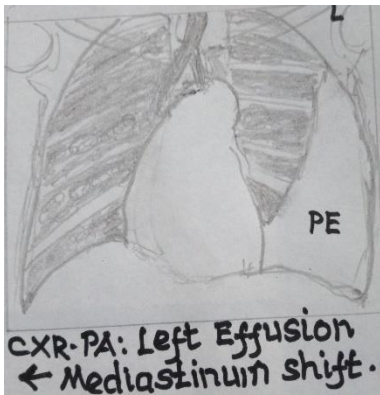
Chest PA Xray film showing large left sided pleural effusion with mediastinal shift to the right
